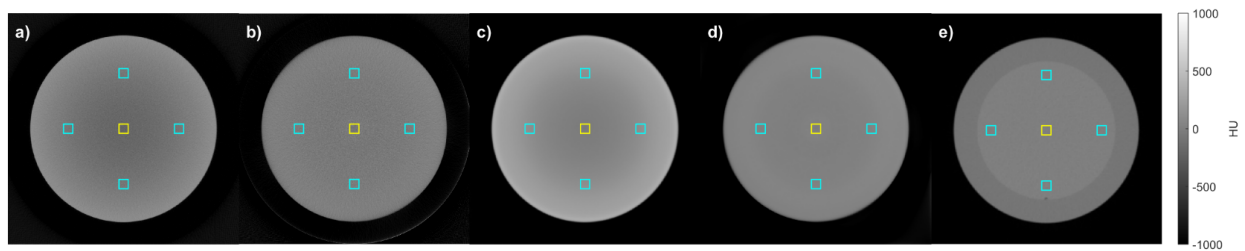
CTP486 uniformity analysis and central line profiles showing cupping artifact recovery for (a) uncorrected FDK, (b) SPS corrected FDK, (c) uncorrected IR TV, (d) SPS corrected IR TV, and (e) clinical CT control comparison.
